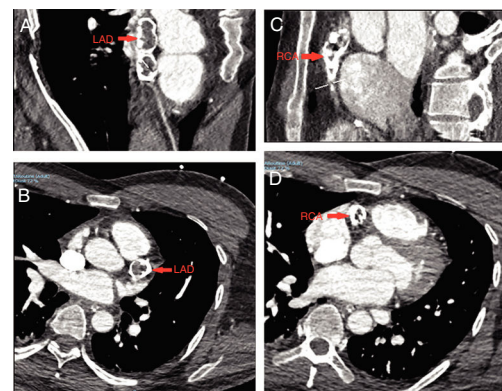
Transverse (B, D) and parasagittal (A, C) CTA images. Ectatic left anterior descending coronary artery (LAD; red arrows in A and B) and right coronary artery (RCA; red arrows in C and D) with intraluminal calcification.
